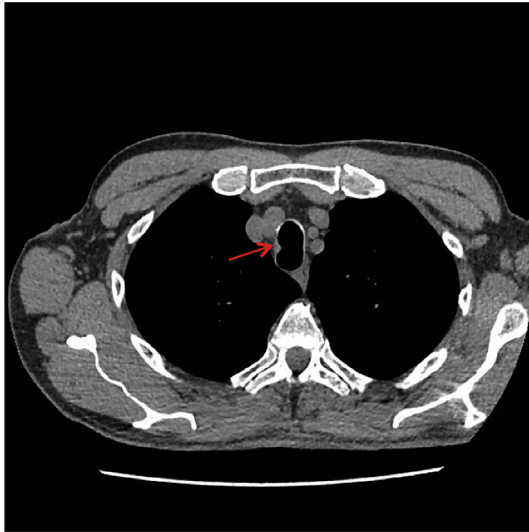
Chest CT showed a 6mm polypoid lesion at the right lateral aspect of the proximal trachea.
